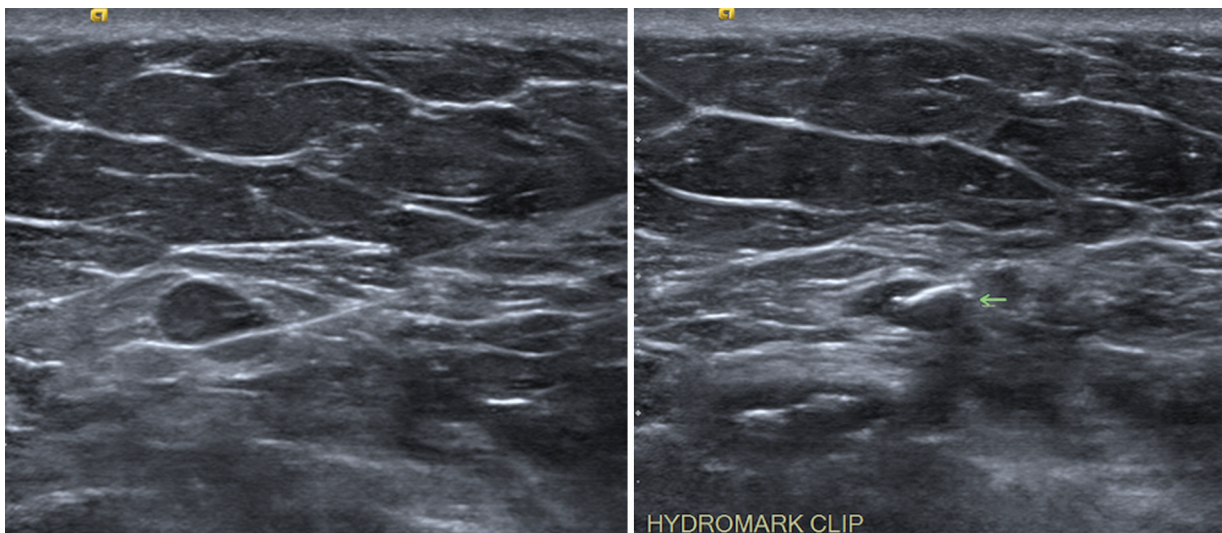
Targeted left breast ultrasound demonstrated a hypoechoic solid mass with indistinct margins, measuring $0.8 \times 0.9 \times 1.1$ cm, at 7:00, 5 cm from the nipple.
